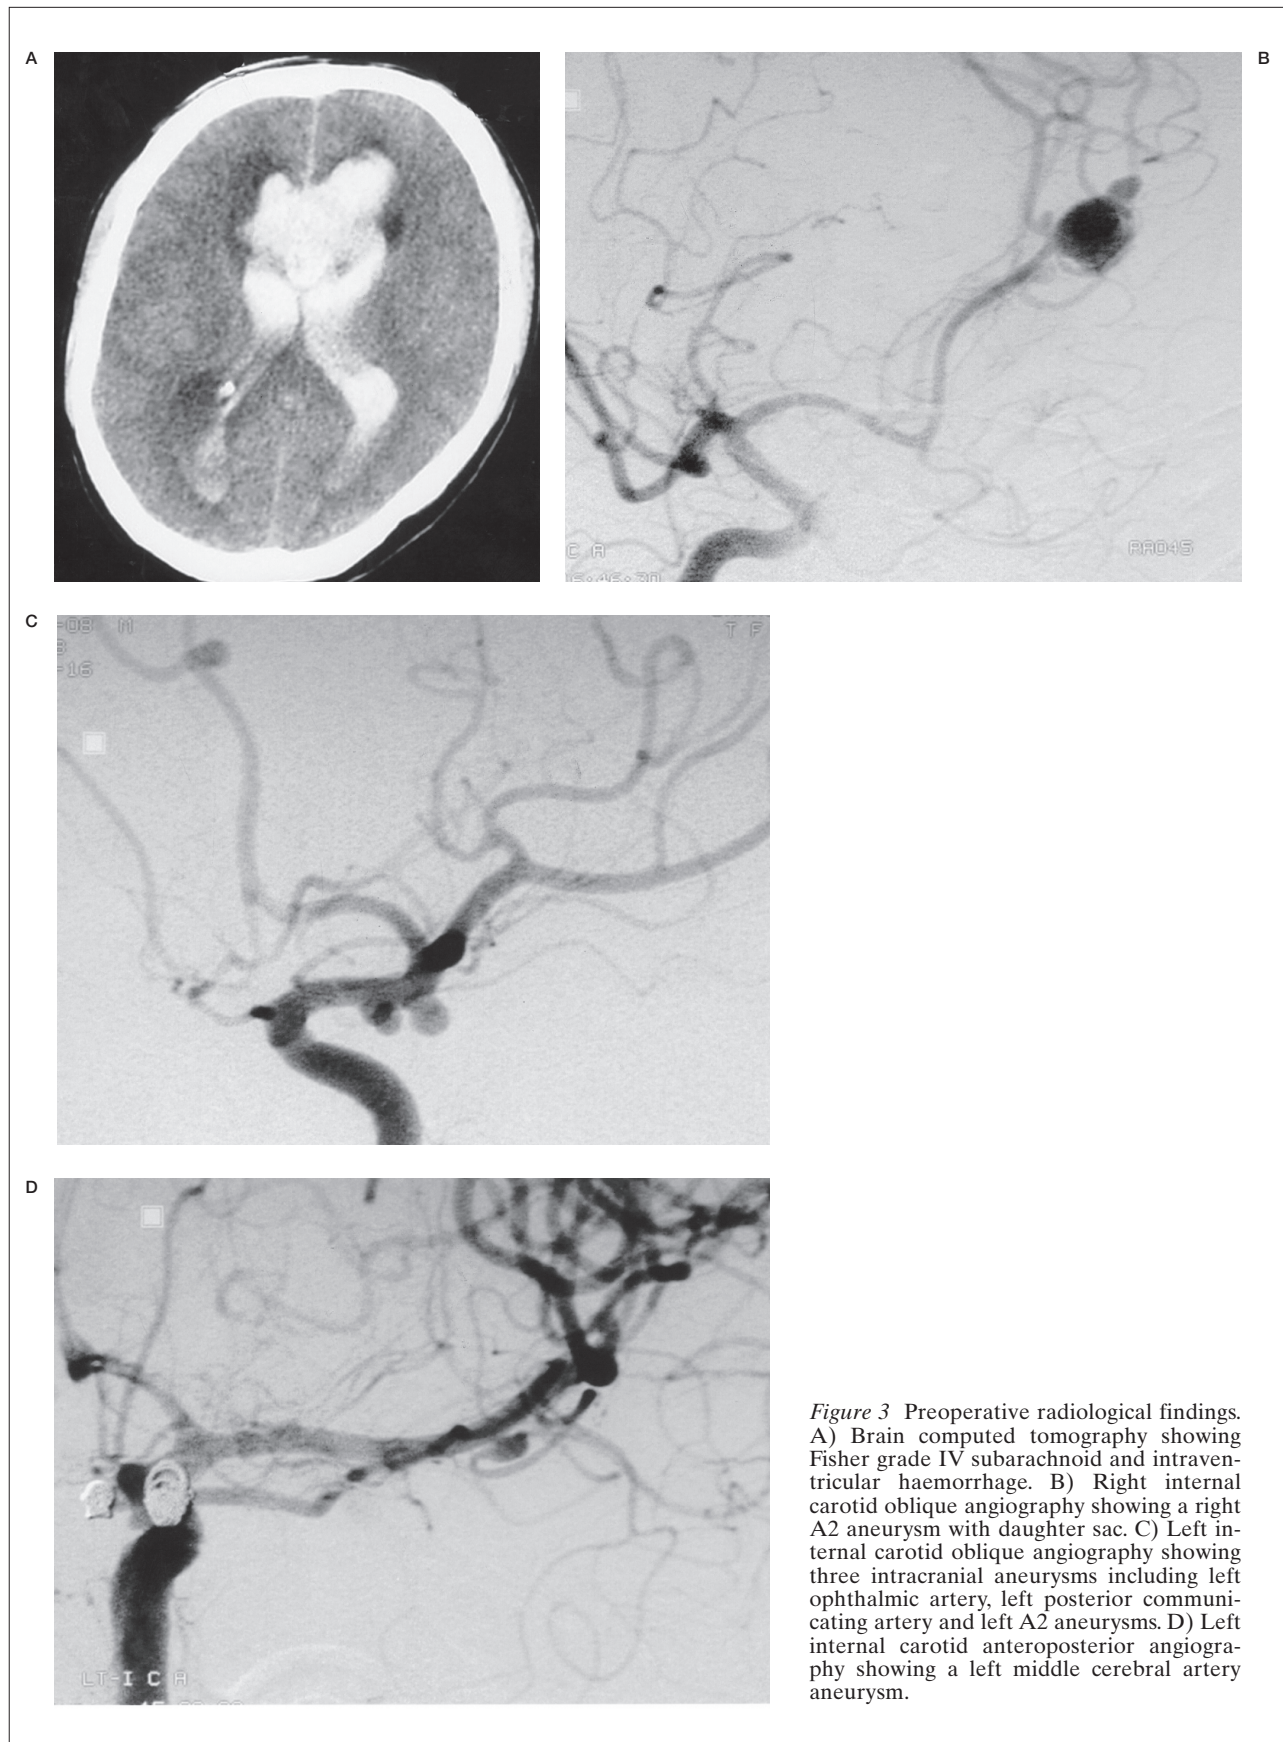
Preoperative radiological findings. A) Brain computed tomography showing Fisher grade IV subarachnoid and intraventricular haemorrhage. B) Right internal carotid oblique angiography showing a right A2 aneurysm with daughter sac. C) Left internal carotid oblique angiography showing three intracranial aneurysms including left ophthalmic artery, left posterior communicating artery and left A2 aneurysms. D) Left internal carotid anteroposterior angiography showing a left middle cerebral artery aneurysm.
